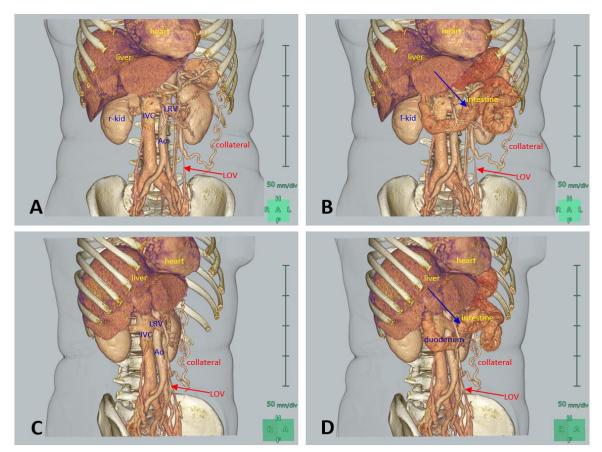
CT Reconstruction with/without the Images of Intestine
